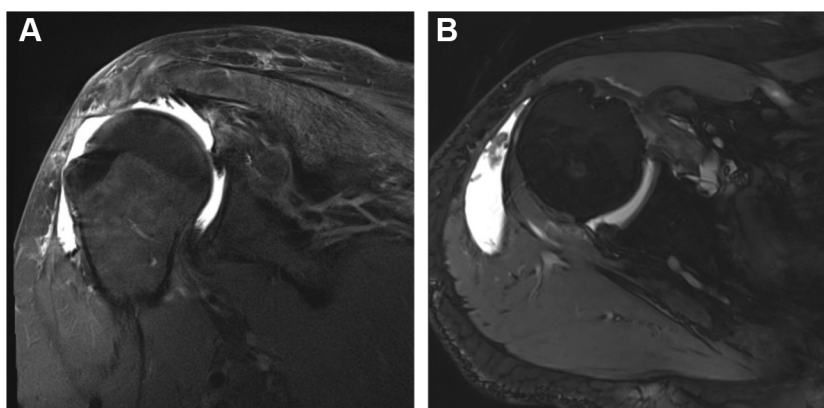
MRI at the second consultation. (A) Paracoronal image showing the avulsed deltoid from its origin at the acromion and lateral clavicle with a dehiscence of the detached deltoid of 6 cm. (B) Axial image showing the disrupted anterolateral deltoid. The posterior portion of the deltoid remained intact.
